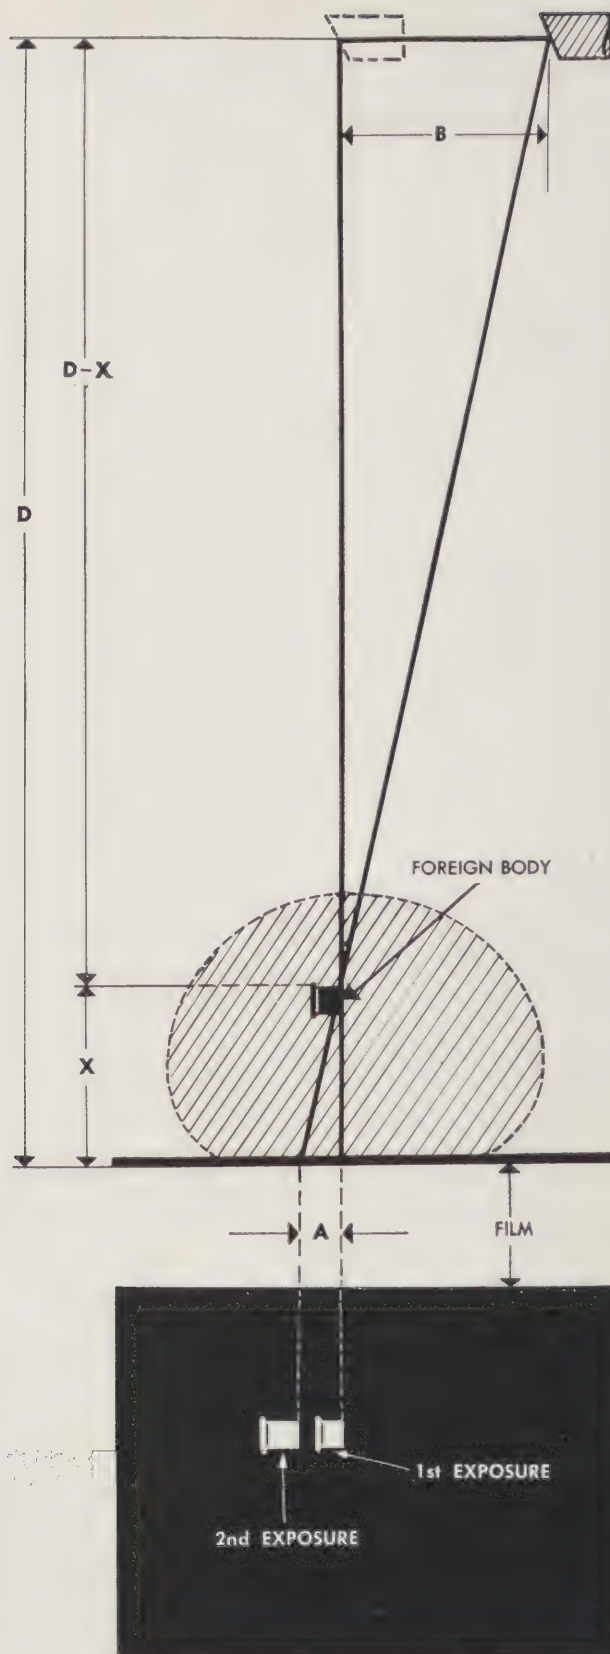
A simple roentgenographic method for foreign body localization.
